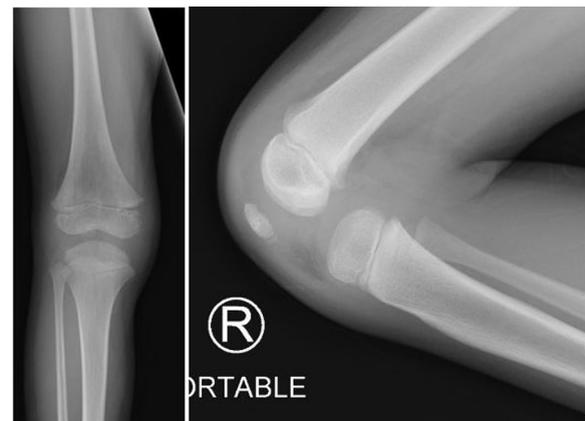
Plain radiographs of the right knee at time of original presentation.
